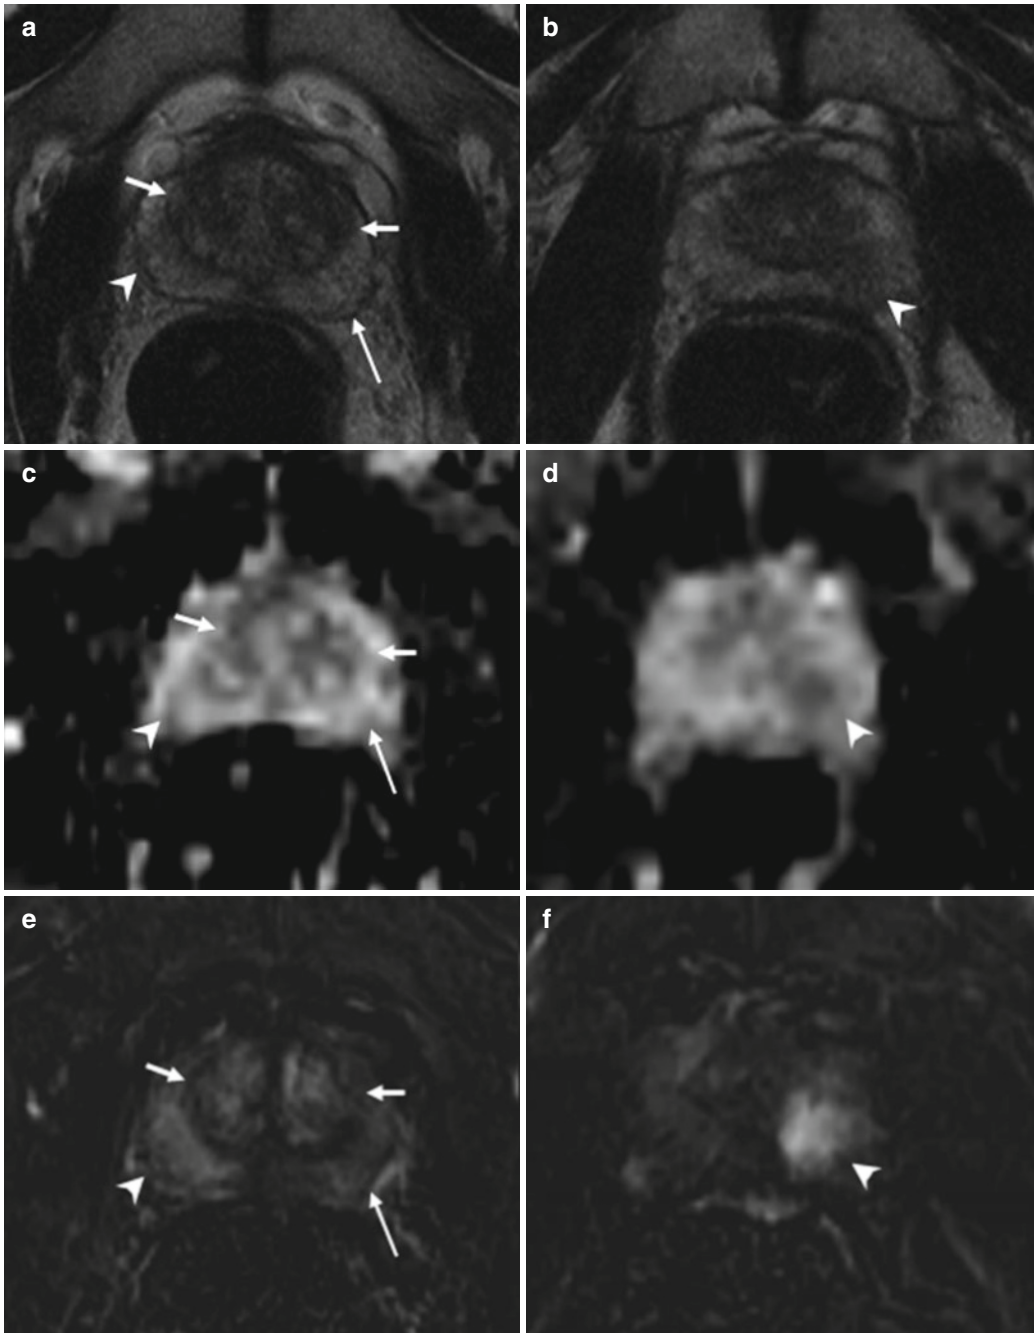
(a–f) 58 years old, PSA 6 ng/ml, Gleason 6 (3+3). (a, c, e) axial sections at the lower third. (b, d, f) axial sections at the middle third. (b, d, f) T2-weighted images; (c, e) ADC images; (e, f) post-contrastographic phase images. Central zone of the prostate (*short arrows*); peripheral zone of the prostate (*long arrows*); abnormal finding (*arrowheads*). (a, c, e) T2-weighted (TR: 3600; TE: 116) (a) and ADC (c) sequences show increased volume of the central zone of the prostate (estimated volume of 35 ml), with inhomogeneous hypointense appearance; the peripheral zone of the prostate appears homogeneous hyperintense. Both T2-weighted and ADC sequence prove no abnormal
